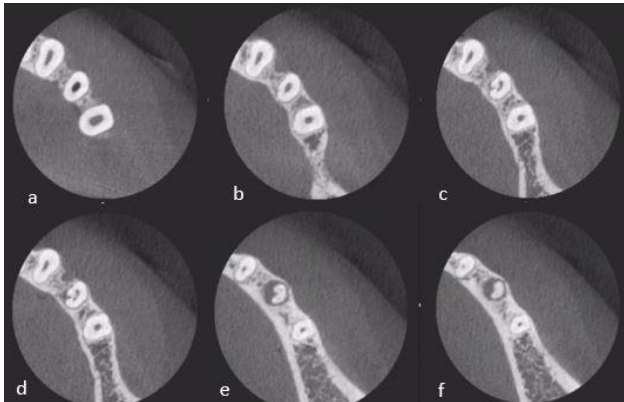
A CBCT scan of the C-shaped left mandibular first premolar axial view: A and B) Radicular coronal third; C and D) Radicular middle third; E and F) Radicular apical third
